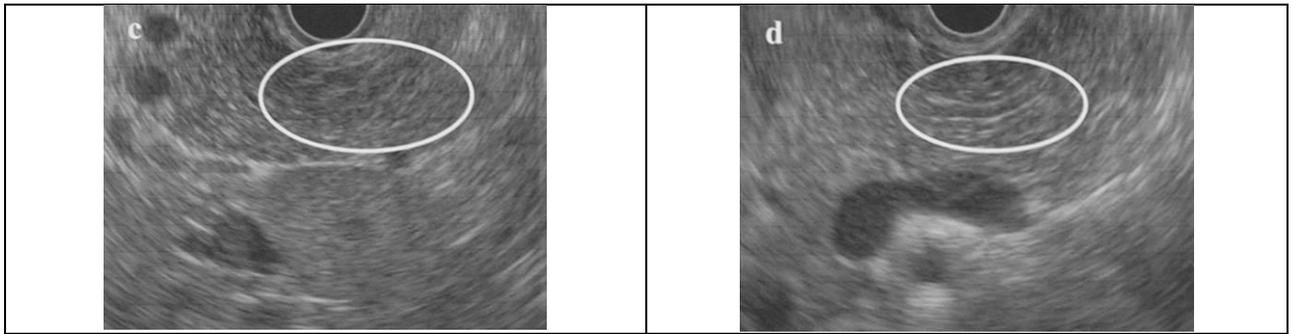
An example of pancreatic endosonography data for early CP (according to T. Ito et al., 2016 [8]): a — lobulation without cellularity; b — hyperechoic tricks without shadow; c — thin strands; d — hyperechoic wall of the main duct.
